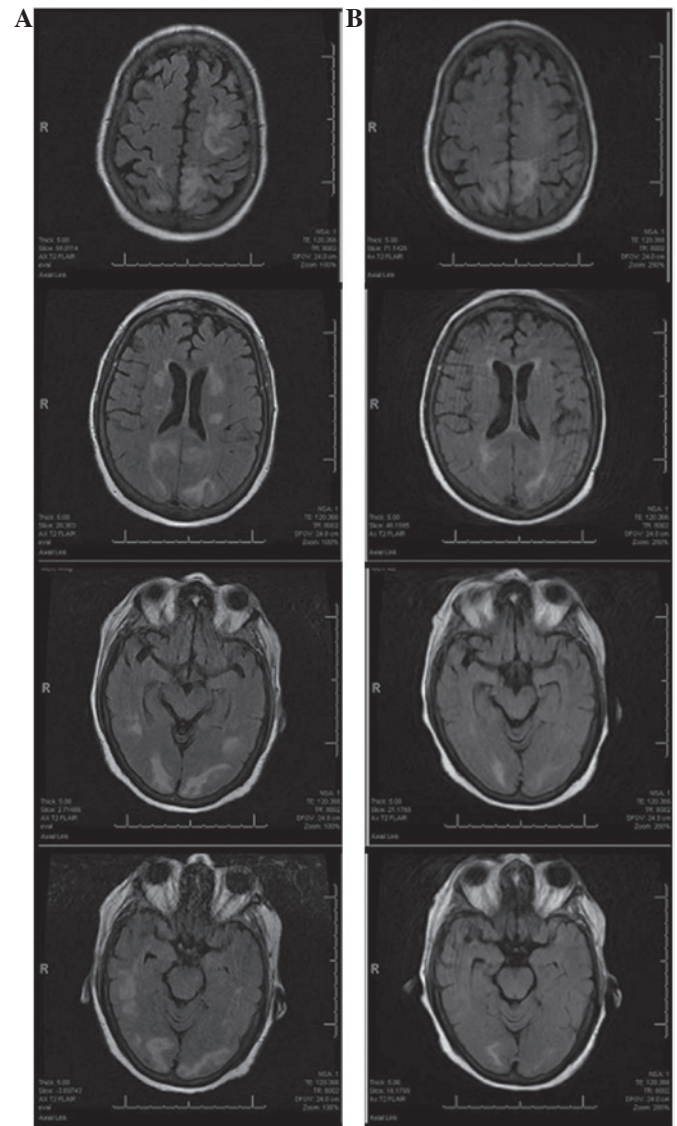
Reversal of diffusion abnormalities in a 65-year-old woman with reversible posterior leukoencephalopathy syndrome associated with cisplatin/pemetrexed treatment. T2-weighted magnetic resonance imaging indicated bilateral regions of increased signal intensity in the occipital, temporal and periventricular white matter (A) upon admission and (B) during the follow-up examination 10 days later, following supportive and symptomatic therapy.
